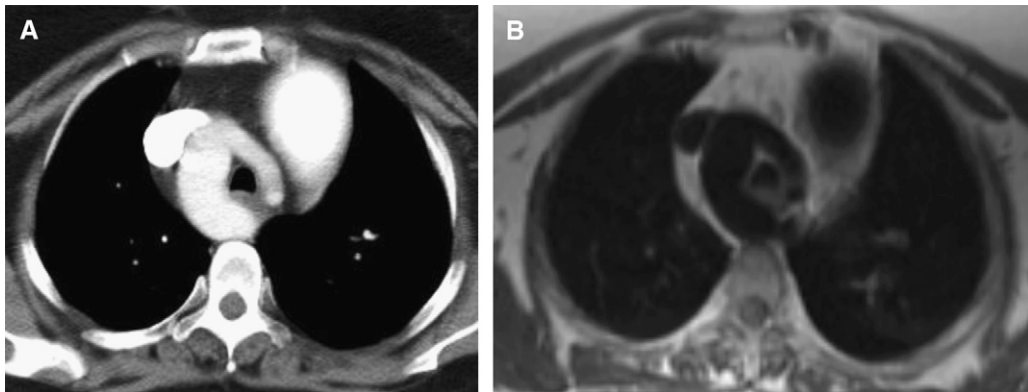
A 35-year-old woman who presented with dysphagia. (A) Transaxial contrast enhanced CT image, showing a vascular ring encircling the trachea and esophagus. (B) Transaxial T1-weighted “black blood” MRI sequence also showing the double aortic arch.
